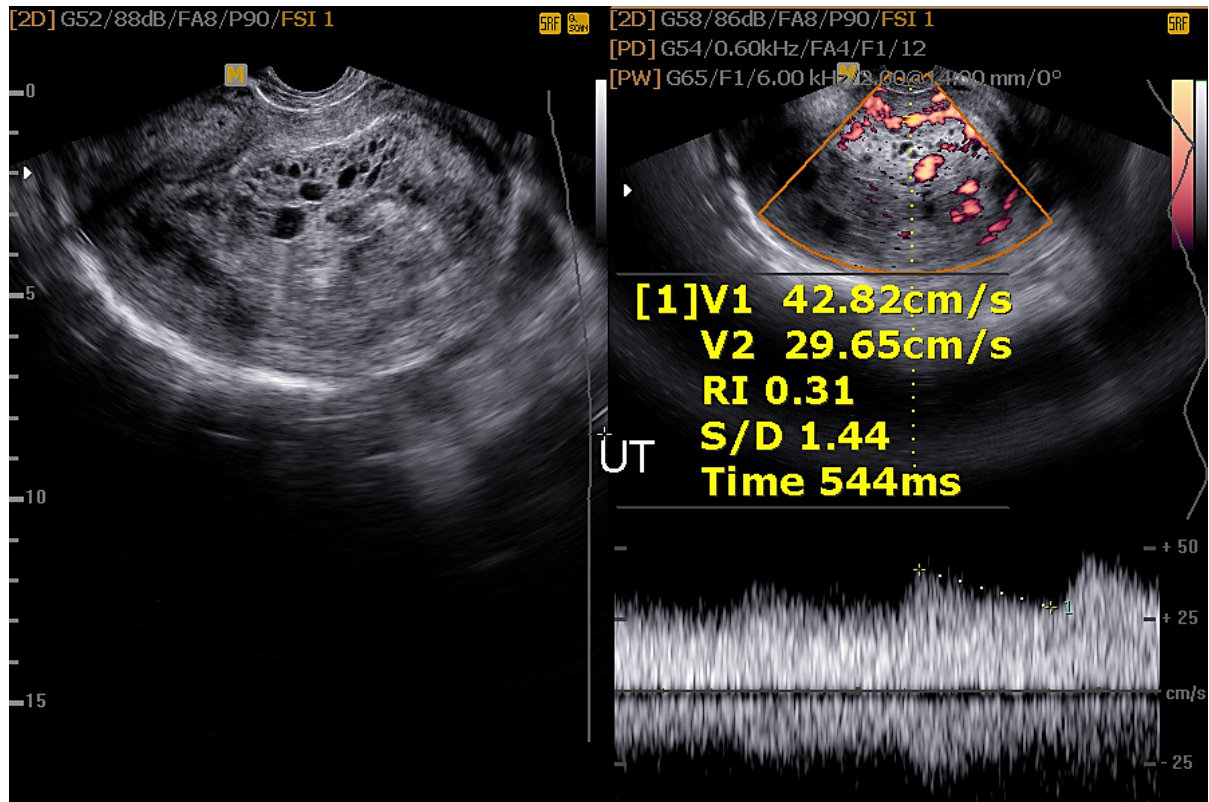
Transvaginal CD sonography examination showing large ill-defined echogenic myometrium mass with cystic changes inside and hypervascularity in a patient presenting with recurrent vaginal bleeding following a suction and evacuation of molar pregnancy, suggesting invasive mole
